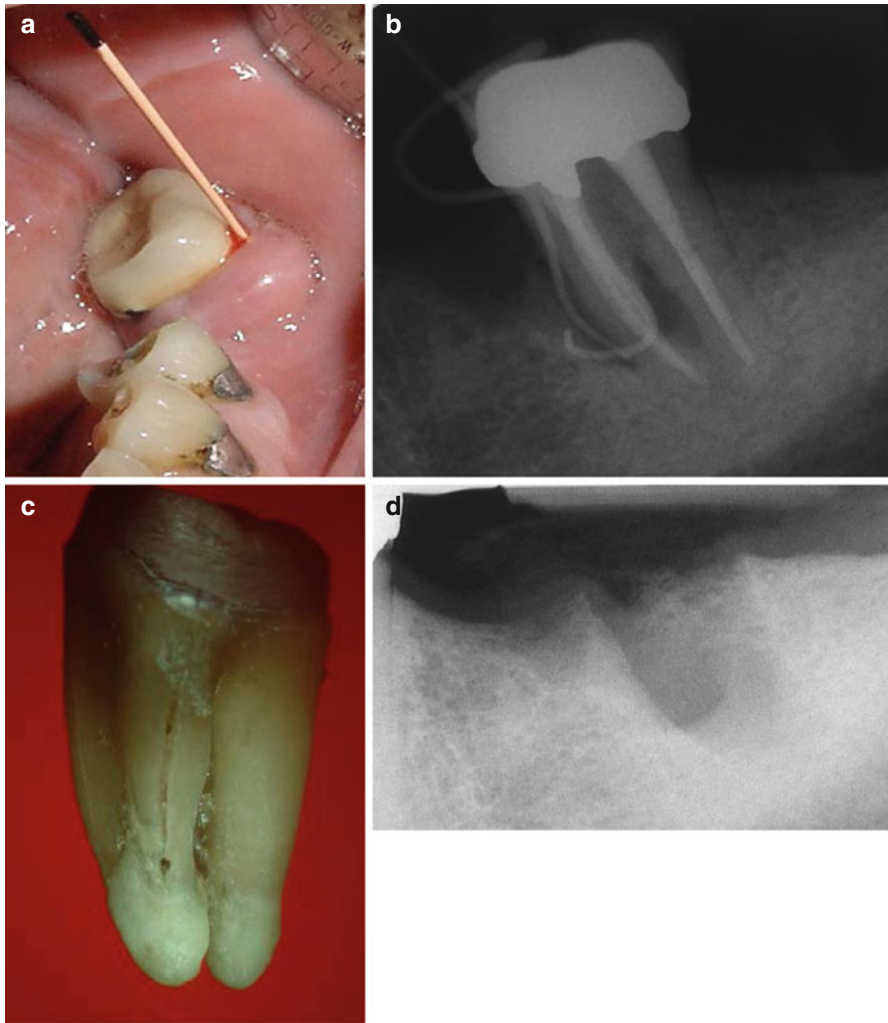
(a–d) The patient arrived at the dental office with “soreness on biting for the last couple of months and a swelling in the area about a year ago.” The first mandibular molar was extracted 5 years earlier but only the second molar endodontically treated, restored with amalgam dowels in the coronal 3 mm of the two roots and a crown (a). Clinical examination revealed sensitivity to percussion and two 8 mm probing defects both in the buccal and lingual aspects. The periapical radiograph (b) shows two gutta-percha tracing cones at the bone resorption area in the coronal two-thirds of the mesial root. A VRF diagnosis was made and the tooth extracted. In the extracted tooth (c), the fracture in the coronal two-thirds of the mesial root can be seen. A periapical radiograph of the extracted site (d) shows the amount of bone loss in the bone as a result of the continuous inflammatory process in the area (Courtesy Prof. J. Nissan)
